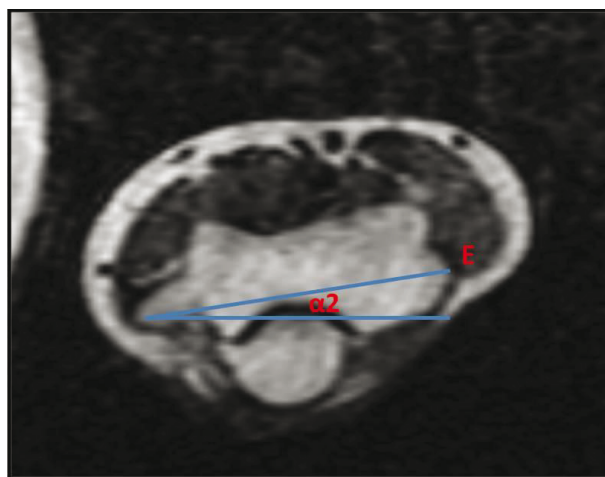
The transepicondylar line was marked and referred to as line E. The angle between the E axis and the line horizontally lying on the articular surface was referred as α_2 . HTA was calculated using axial MRI images [$HTA = (\alpha_1 - \alpha_2)$] (12).
